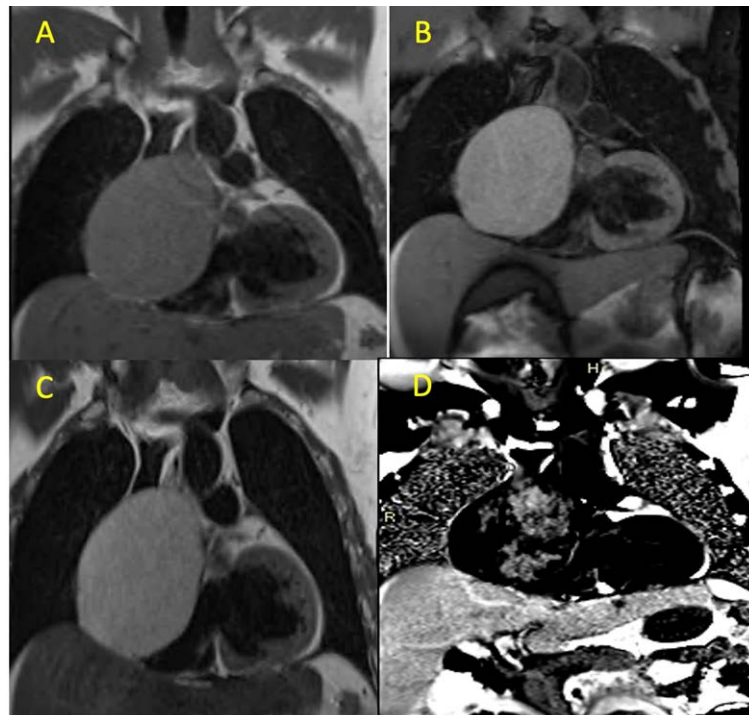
Cardiac MRI showing a large sessile (not pedunculated), non-mobile mass in the interatrial septum appearing homogeneous and iso-intense to the myocardium on T1W (A) with no change on T1W FS(B). T2W shows the mass as homogenous and hyper-intense relative to the myocardium (C). Injection of gadolinium contrast showed intense, non-homogeneous delayed hyperenhancement on Phase-sensitive inversion-recovery (PSIR) (D).
